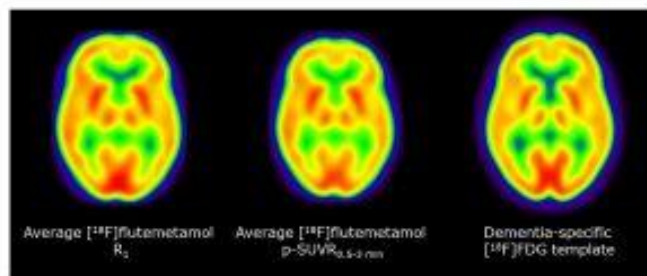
Spatially normalized average images for  $R_1$  (left) and early-phase perfusion SUVR (p-SUVR) over the optimal time window 0.5-3 min post injection (middle) across all six subjects. Right hand image shows a dementia-specific [18F]FDG template, based on 100 subjects, for comparison (Della Rosa et al., Neuroinformatics, 2014).
